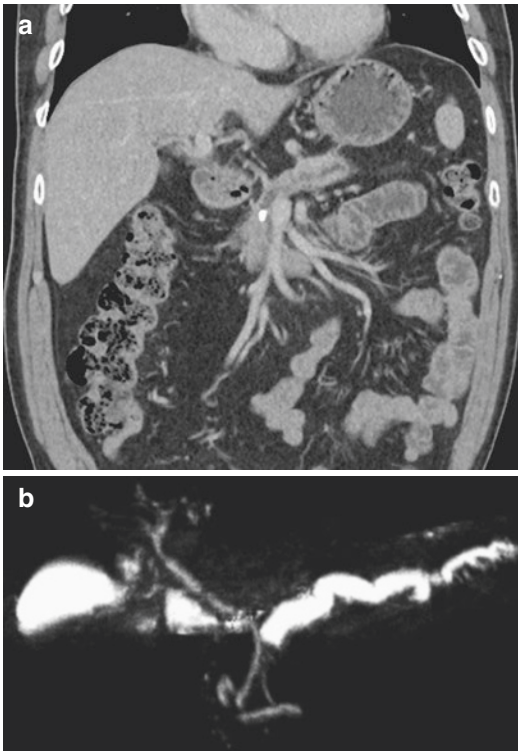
(a) Computed Tomography of a patient with a calcific stone at the pancreatic genu. (b) Magnetic resonance cholangiopancreatography of the same patient with ductal stone at the genu, upstream ductal dilation and a convoluted downstream ventral pancreatic duct
